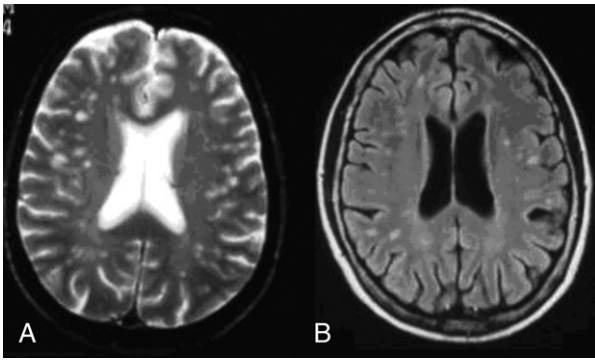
Brain magnetic resonance imaging showing small, punctate, bright areas of increased signal on (A) T₂-weighted and (B) fluid-attenuated inversion recovery (FLAIR) sequences subcortically located, indicating vasculitis. (Courtesy of Professor Stefano Bastianello.)
